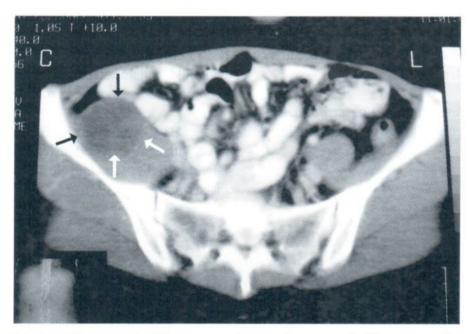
Enhanced axial CT scan reveals rim enhancement of the mass with central hypodensity.
